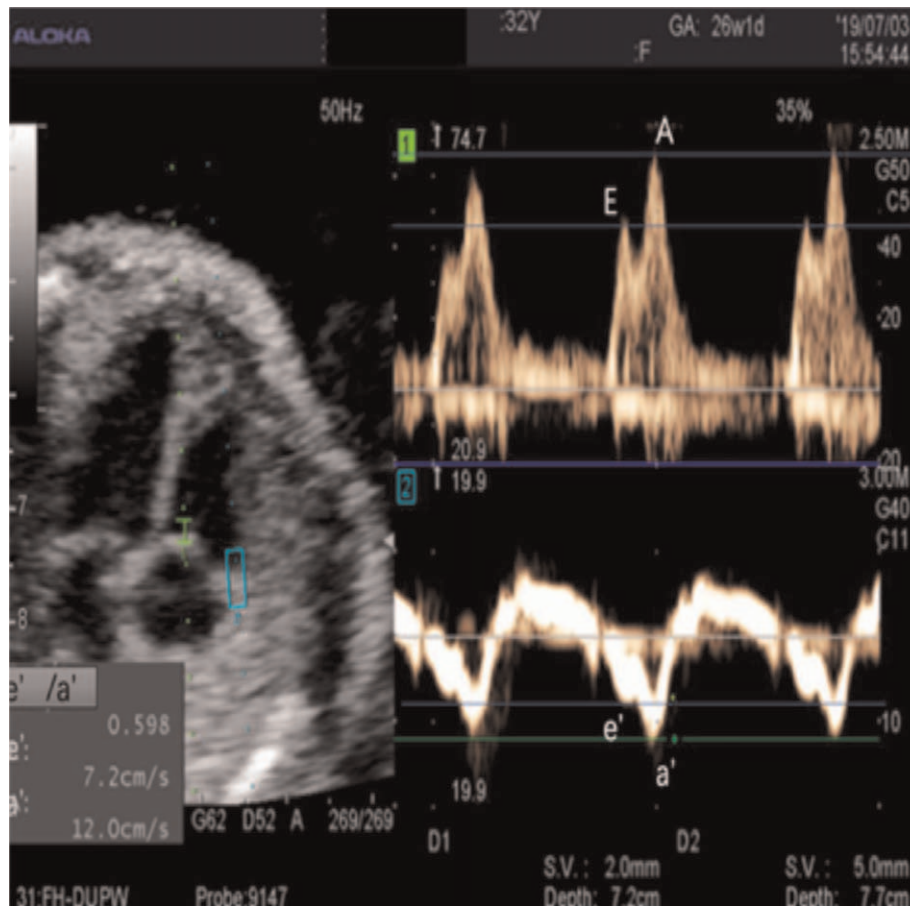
A represented graphic showing an apical/basal four-chamber view of measurement of fetal tricuspid inflow Peak wave velocities (peak E and peak A) and tricuspid annular peak wave velocities (e' and a') using dual-gate Doppler. In the left panel, PW Doppler spectrum (shown in bright green) was placed just below the tricuspid valve leaflets, while TDI Doppler spectrum (shown in cyan blue) was placed in the tricuspid valve annular. In the right panel, Upper waveform obtained using pulsed-wave Doppler imaging and lower waveform using tissue Doppler imaging.
